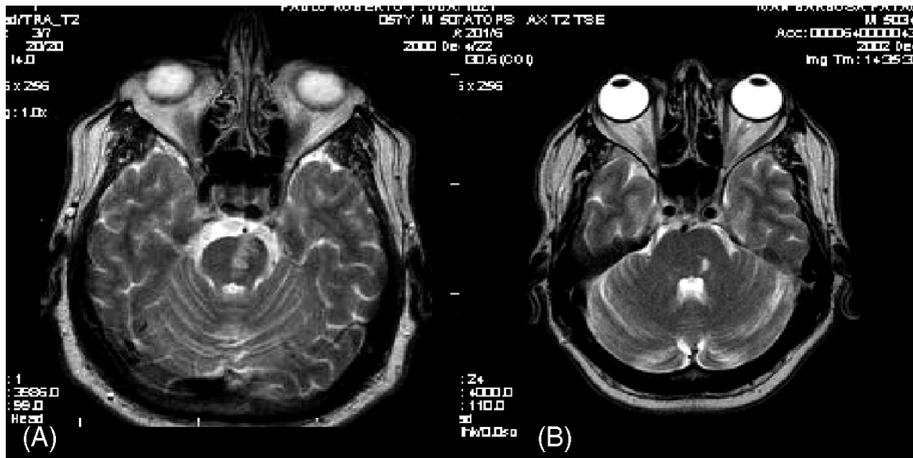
(A) A 57-year-old hypertensive diabetic man presented with right hemiplegia and hemianesthesia involving the face, arm, and leg, severe dysarthria, and left extraocular palsy. The MRI showed a large pontine infarct caused by basilar atherosclerotic stenosis (“branch disease”). (B) A 62-year-old hypertensive man presented with a sudden painful feeling in his left eye and nose (“salt and pepper in the face” pain) and mild right hemiparesis. The MRI showed a small tegmental pontine infarct, probably caused by small-artery disease.
